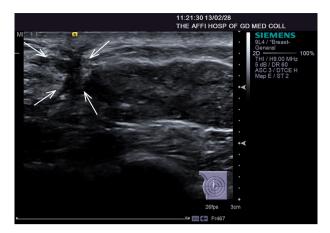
Ultrasound image of an irregular, hypoechoic, postsurgical breast scar (white arrow) adjacent to the mass.
